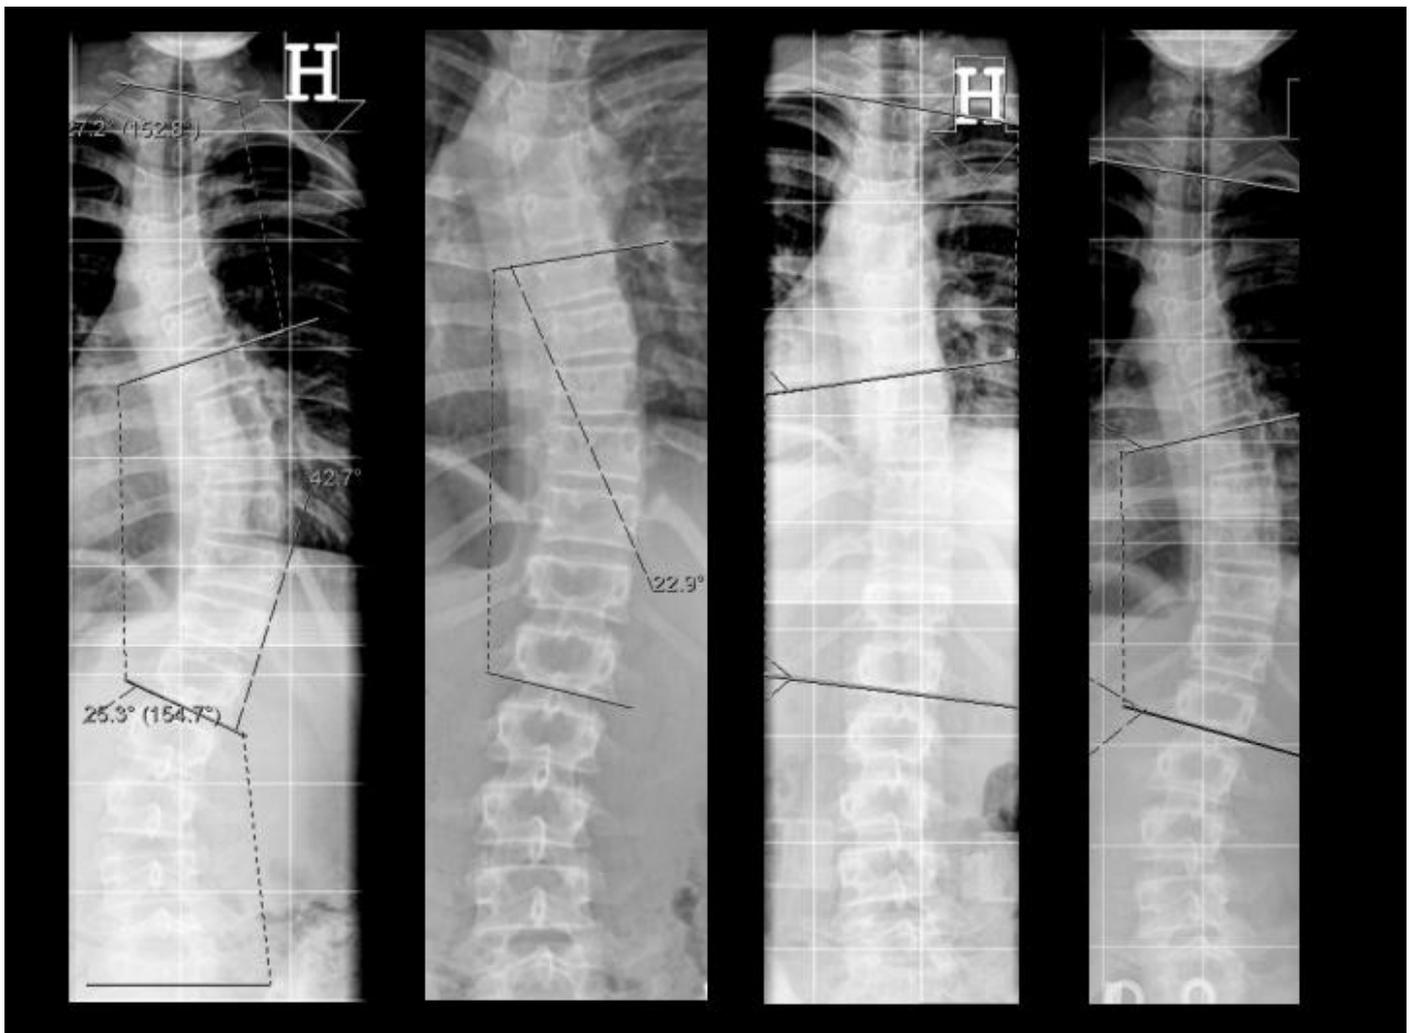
Radiographs showing a right convex primary curve of 42.7° in a girl with adolescent idiopathic scoliosis who started bracing at age 12 years. She had no signs of growth maturity, Risser was 0, and she had not had menarche. She was highly compliant and used the brace about 20 hours daily. The curve was flexible before bracing and was reduced to 22.9° lying prone, to 15.6° in a rigid brace (indicating good brace fit), and the primary curve was 32.0° at brace weaning. She participated in sports 1-2 hours daily.
